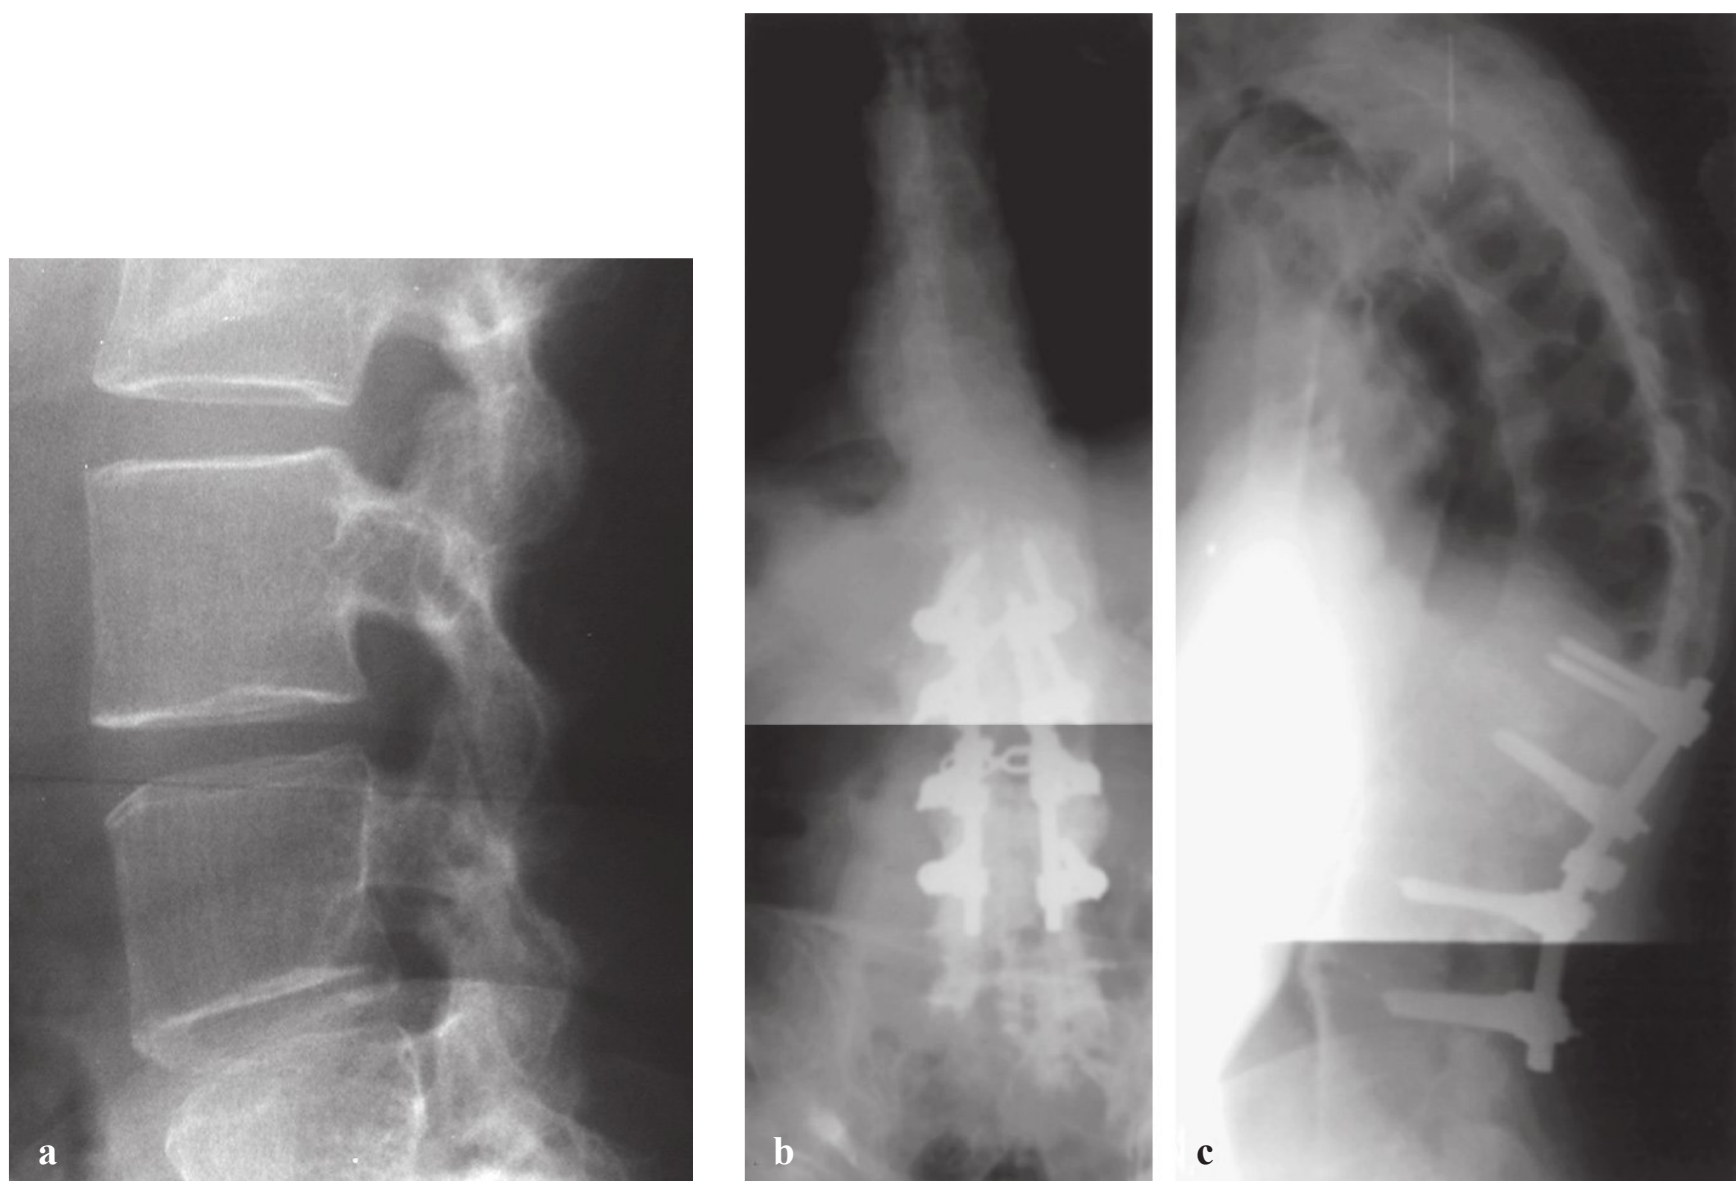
(a) Lateral radiograph of a patient with ankylosing spondylitis with severe sagittal plane imbalance. (b) Anteroposterior radiograph following an L2 pedicle subtraction osteotomy. (c) Lateral radiograph shows the osteotomy site at L2 with correction of the positive sagittal balance. (Fig. 26.1a from Imhof H, ed. *Spinal Imaging (Direct Diagnosis in Radiology)*. Stuttgart, Germany: Georg Thieme Verlag; 2008: Fig. 4.18. Reproduced with permission.)
